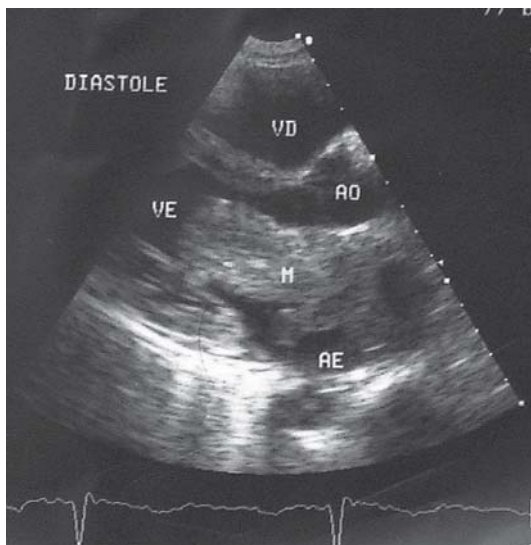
Two dimensional echocardiogram test during diastole showing the tumor projecting into the left ventricle. Ao = aorta; VD = right ventricle; VE = left ventricle; M = tumor mass; AE = left atrium
